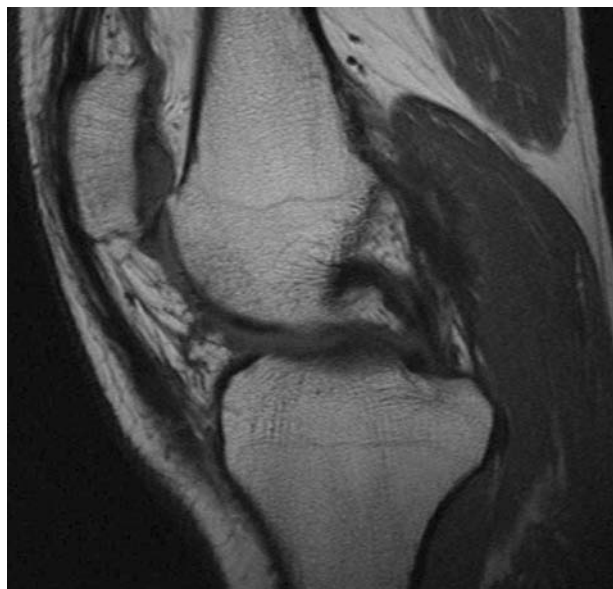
Typical MRI of a patient with transplant hypertrophy following periosteum-covered autologous chondrocyte implantation for a patellar cartilage lesion.
